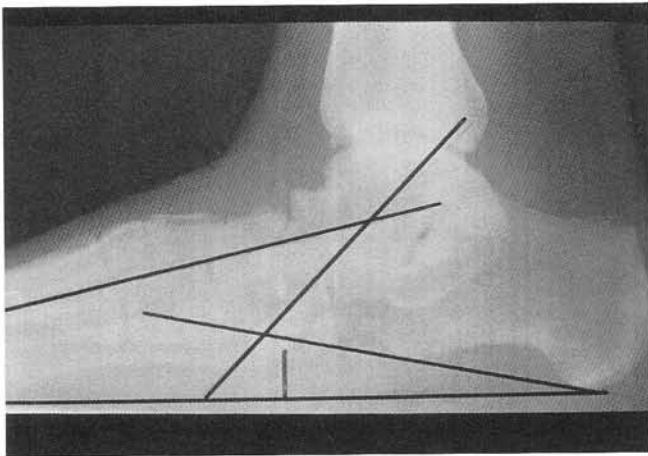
Lateral weight bearing radiograph of a patient with adult acquired flatfoot syndrome secondary to longstanding tibialis posterior tendon dysfunction. Note the adaptive and secondary changes at the talar neck area.
